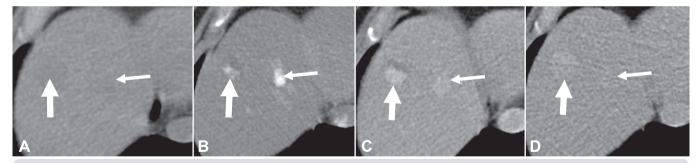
Type I (thick arrows) and type II (thin arrows) hemangiomas on dynamic CT. Pre-contrast (A), arterial (B), portal-venous (C), and delayed (D) phases are shown. Note the enhancement of lesions similar to that of vessels.
